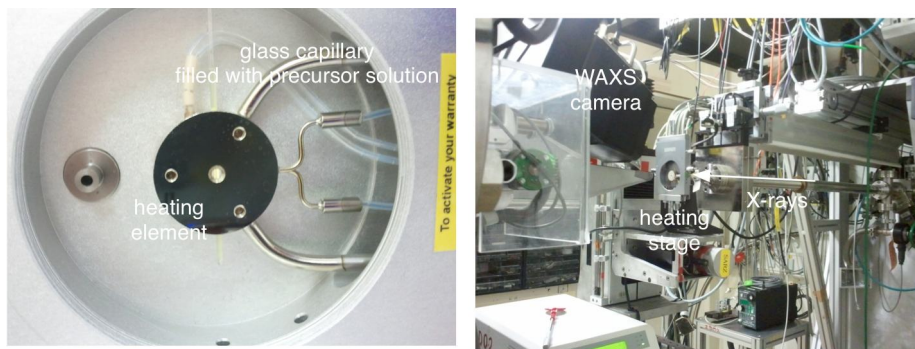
Left : Linkam hotstage with a capillary filled with a precursor solution. The metal round part can be heated at the desired temperature and the X-rays go through the capillary through the hole at the center of the heated piece. Right : the hot stage set-up
